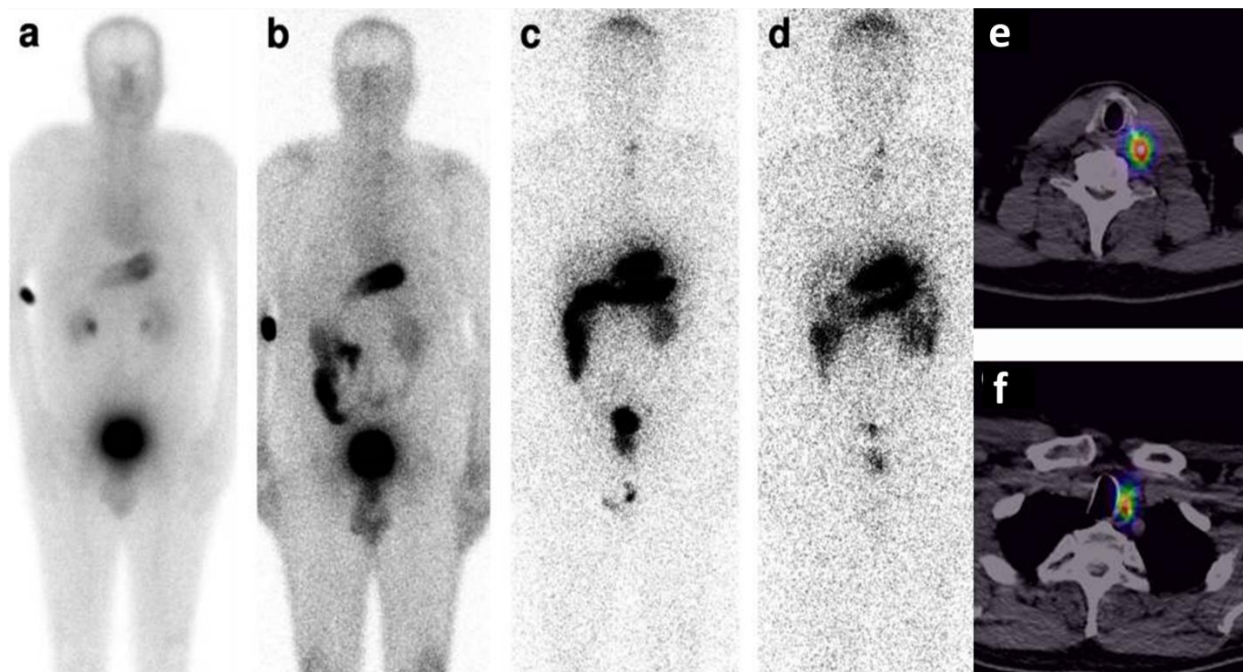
Exemplary whole body dynamic distribution from a clinical GRANT-T-MTC study comprising 16 patients after intravenous administration of [^{111}In]In-CP04 a) immediately after injection, b) at 1 h, c) at 24 h, and d) at 48 h p.i.. e-f) SPECT/CT imaging of two lesions. Copyright © 2022 by Lezaic L, Erba PA, Decristoforo C, Zaletel K, Mikolajczak R, Maecke H, Maina T, Konijnenberg M, Kolenc P, Trofimiuk-Müldner M, Przybylik-Mazurek E, Virgolini I, de Jong M, Fröberg AC, Rangger C, Di Santo G, Skorkiewicz K, Garnuszek P, Solnica B, Nock BA, Fedak D, Gaweda P, Hubalewska-Dydejczyk A (187).
